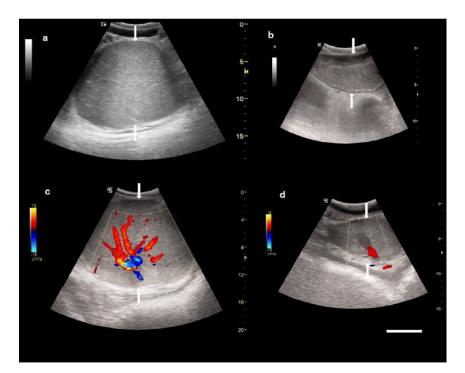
Transrectal ultrasound images of testicles (arrows) of two African elephant bulls prior to gonadotrophin releasing hormone (GnRH) vaccination (a, c) and after 3 years of continuous treatment (8 injections with 1000 μg of GnRH-protein conjugate, dosed every 5–6 months after initial injection and booster after 6 weeks) (b, d), normalized to the same scale: a, bull 1 (8–11 years of age) prior to vaccination showing a round echoic
